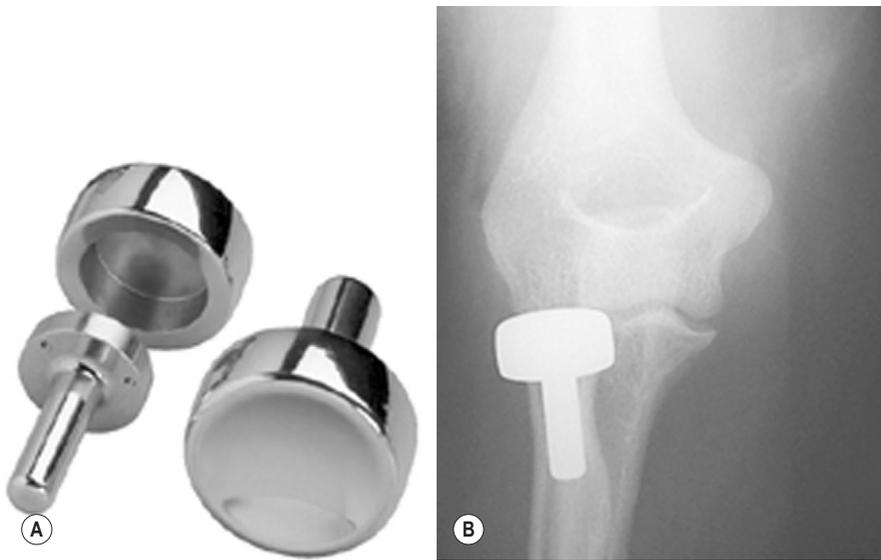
Radial head arthroplasty and the appearance on X-ray. (Reproduced by kind permission of Adam C. Gaines, Wright Medical Technology, TN, USA.)
